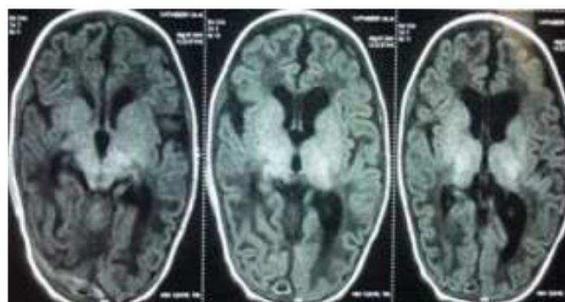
3 MRI showing acute ischemic lesion in internal capsule & corona radiate
